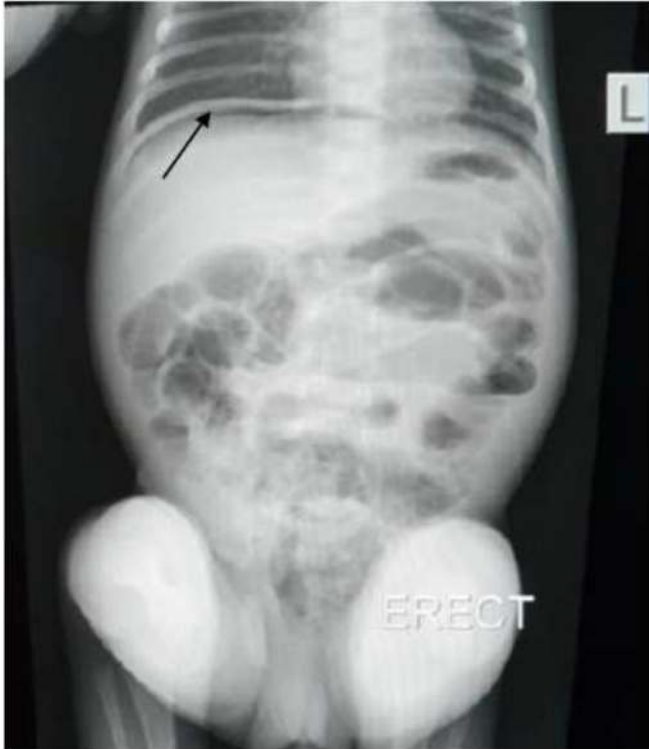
Plain abdominal X-ray showing free air (arrow) under right hemidiaphragm
